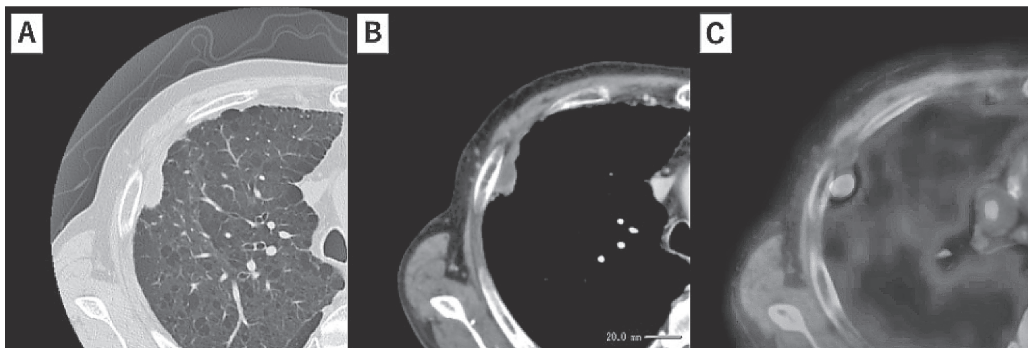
(A) There were emphysematous changes on CT scan. (B) Contrast-enhanced CT scan revealed necrotic space-occupying lesion just behind the 3rd costal bone. (C) Positron emission tomography scan showed mild 2-[fluorine 18] fluoro-2-deoxy-d-glucose (FDG) uptake by the lesion.
